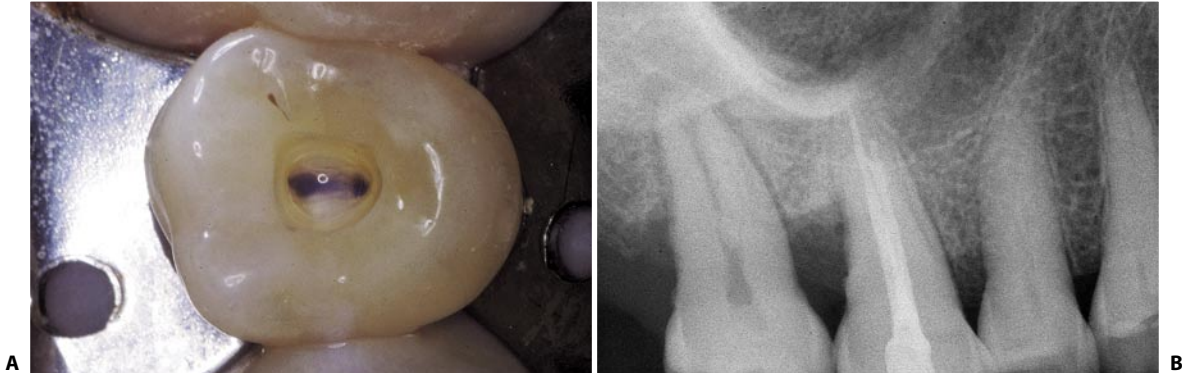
A. The pulp chamber floor of this upper right first molar has two orifices, one palatal and one buccal. B. Postoperative radiograph of the same tooth. The longer palatal canal and a single buccal canal are visible. The latter has a small bifurcation in its apical one third.
